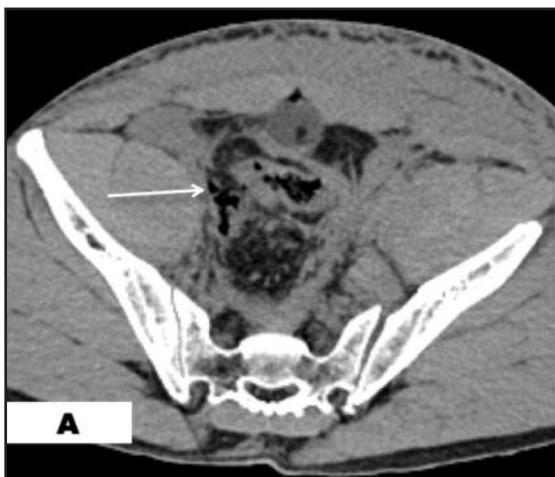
(A & B): Small extraluminal air from a transected rectosigmoid colon. 26-year-old man whose lower abdomen was hit by a falling metal pipe at a factory. Bowel injury was missed on CT scan. Retrospective review of the CT scan in soft-tissue window axial view (A) and coronal MPR (B) showed a subtle extraluminal air (arrow).
